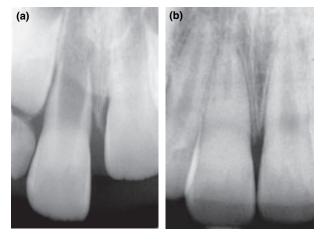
(a) The right central maxillary incisor of a 7-year-old boy was buccally luxated, and showed a wide open foramen. (b) After 4 years, the radiograph shows complete but shorter root formation (compared with the contra-lateral) with pulp canal calcification in the coronal half of the root.
